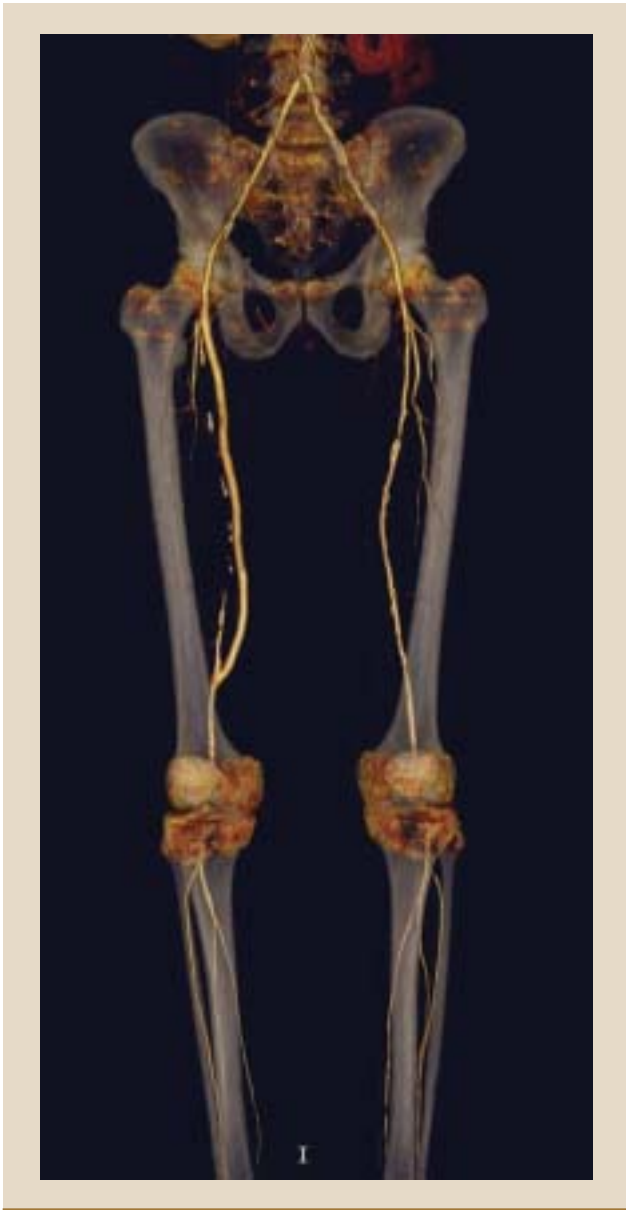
Computed tomographic angiogram showing a patent right femoropopliteal artery bypass graft and focal stenosis of the left superficial femoral artery.
